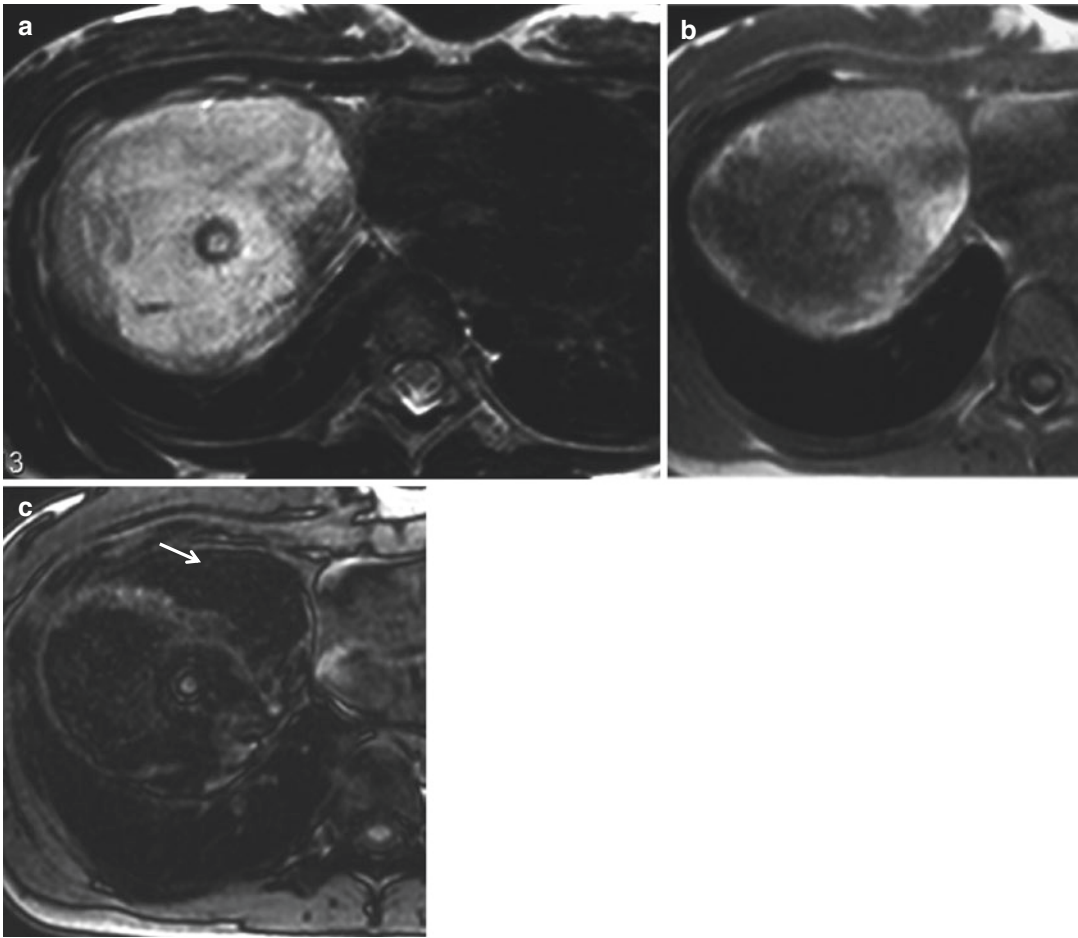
Mature teratoma. A mass with a thick wall, which can be characteristic for mature teratoma, is demonstrated in the right paracardiac region. The mass entirely shows high signal intensity on T2-weighted
